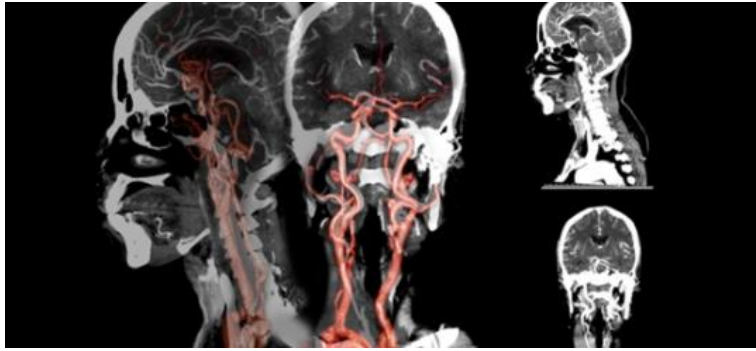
(CT Angiography Of Head And Neck)
